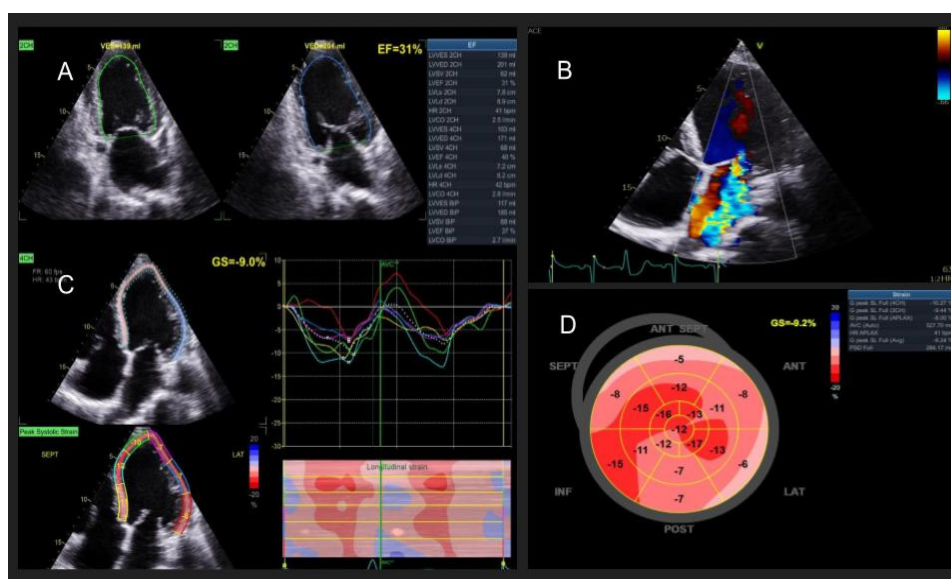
Baseline echocardiography examination: A. LVEF assessment by Simpson biplane method; B. Apical 4-chambers view showed dilated LV with severe MR; C. 4 chamber LV GLS tracing showed reduced 4ch GLS value; D. Average GLS showed reduced value (-9.2 %) (LVEF: Left ventricle ejection fraction; LV: Left ventricle; MR: Mitral regurgitation; GLS: Global longitudinal strain).
